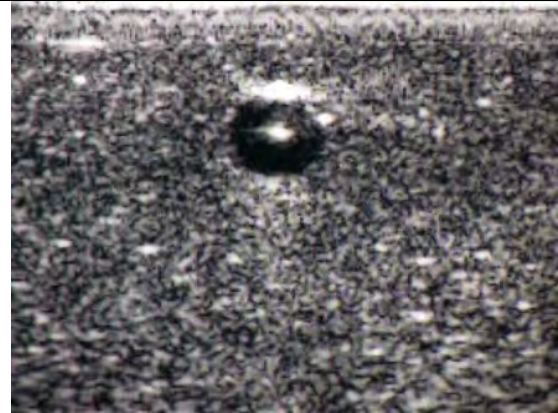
Ultrasound before needle insertion
